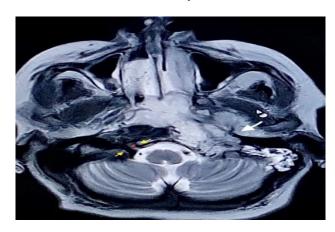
This is a T2-weighted MR venogram of the brain in axial section. The right hypoglossal leaving the hypoglossal foramen. Compare with left side.
